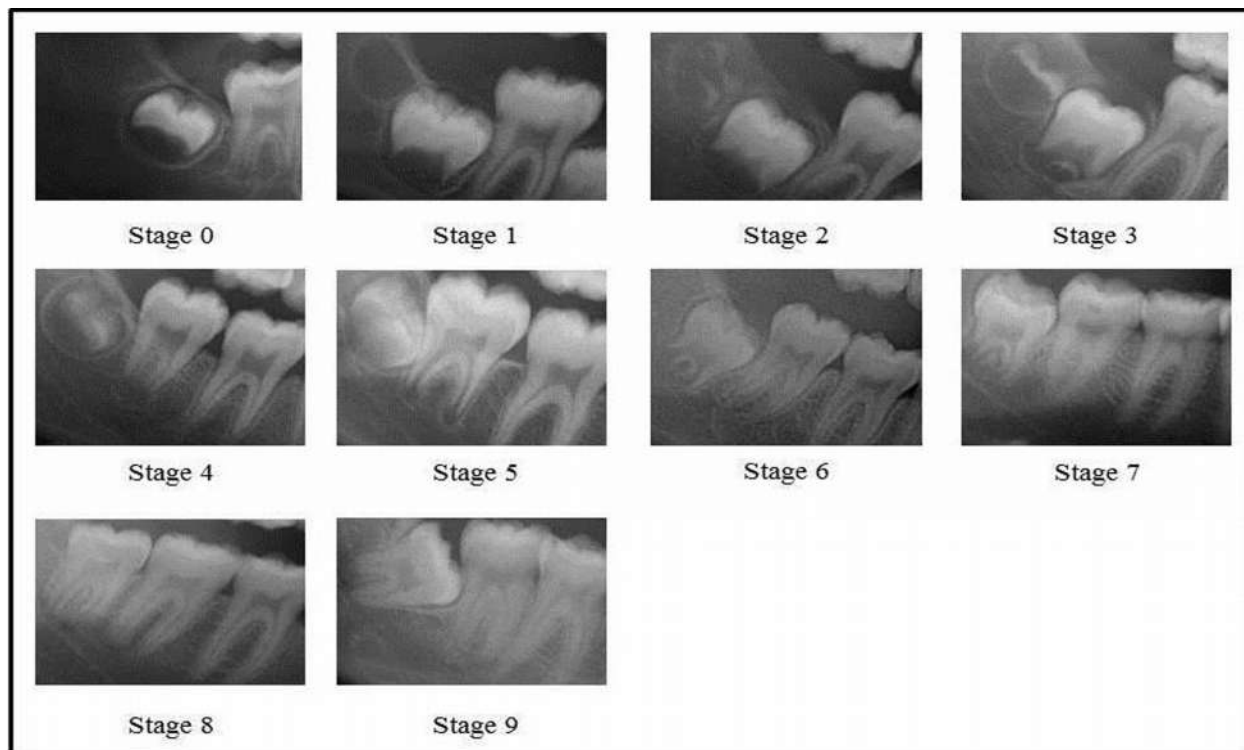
Radiographs showing stages of development of mandibular third molar
